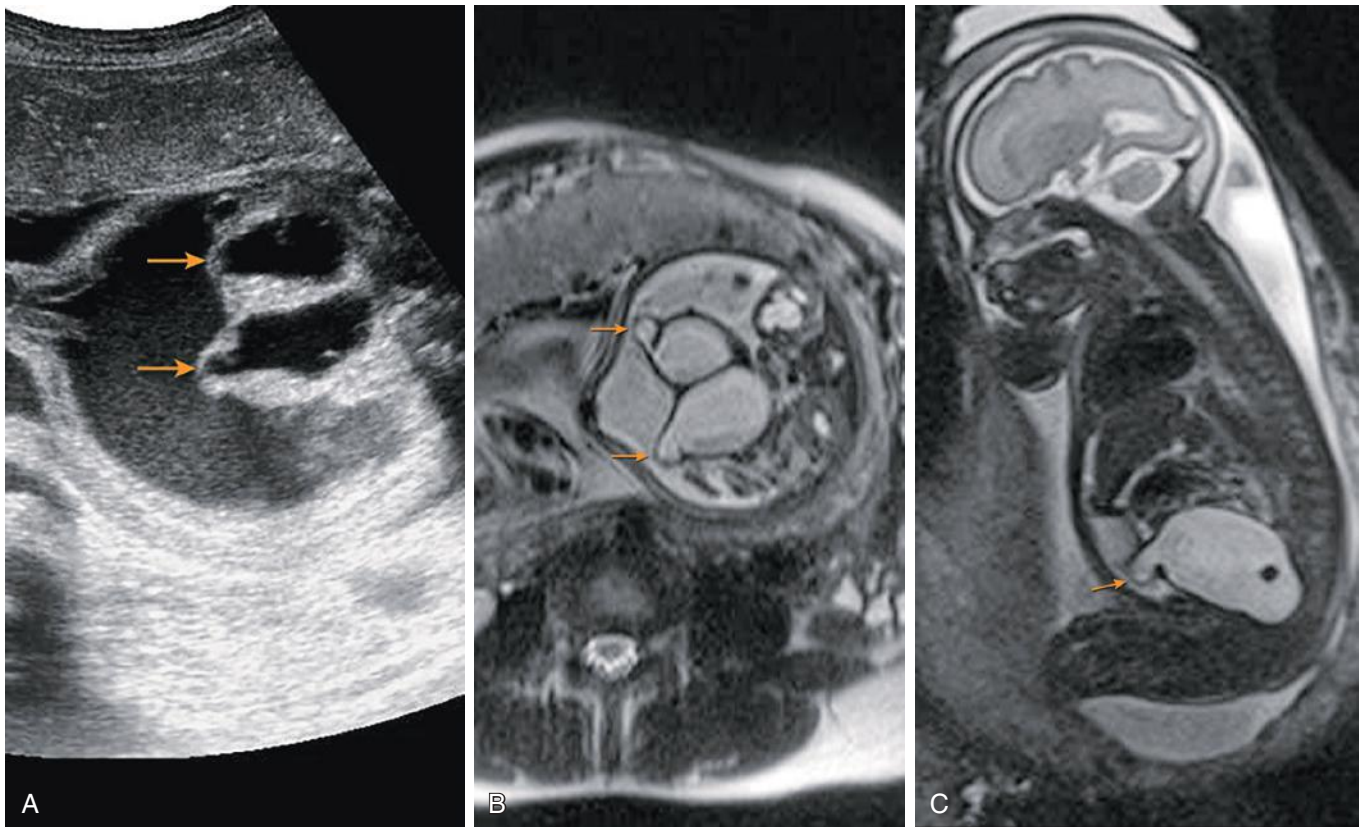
Hydrometrocolpos with uterine duplication in complex cloacal malformation at 31 weeks' gestation. Axial ultrasound image (A) and axial (B) and sagittal (C) magnetic resonance images are shown. Dilated proximal fallopian tubes (*arrows*) communicate with fluid-filled duplicated endometrial cavities. Complex pelvic ascites is adjacent to hydrometrocolpos.
